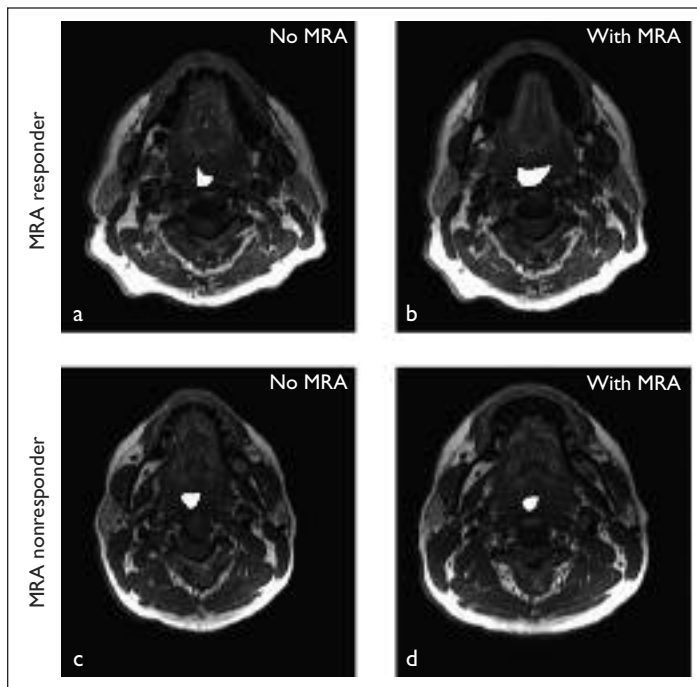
Axial magnetic resonance imaging sections at the retroglottal level in two patients with OSA, taken with and without an MRA. The MRA responder (*a and b*) shows an increase in lateral airway dimensions with the MRA, whereas the nonresponder (*c and d*) does not (airways are highlighted).
